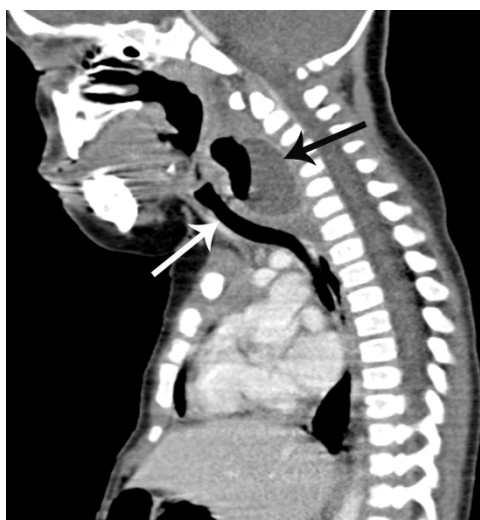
Sagittal CT image shows the anterior displacement of the airway (white arrow) and the retropharyngeal space abscess (black arrow).
